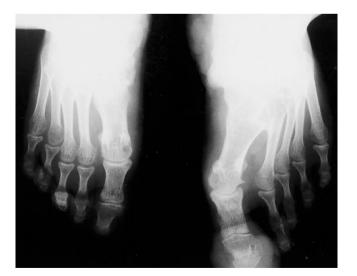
Roentgenogram demonstrated exostosis on the lateral side of the left first metatarsal bone
